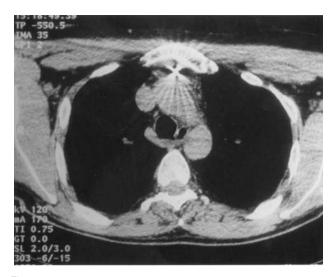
CT scan of chest showing K-wire in anterior mediastinum adjacent to aortic arch
